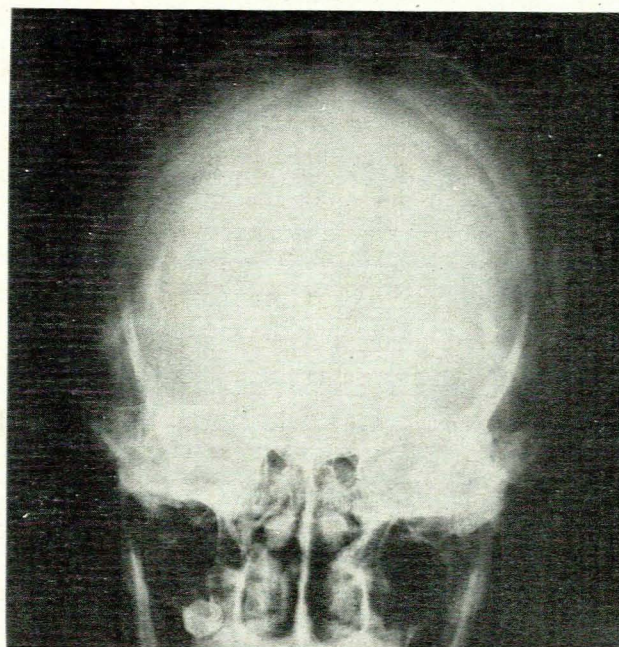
Skull radiograph: the calcified focus in the left side of the brain can be seen.
